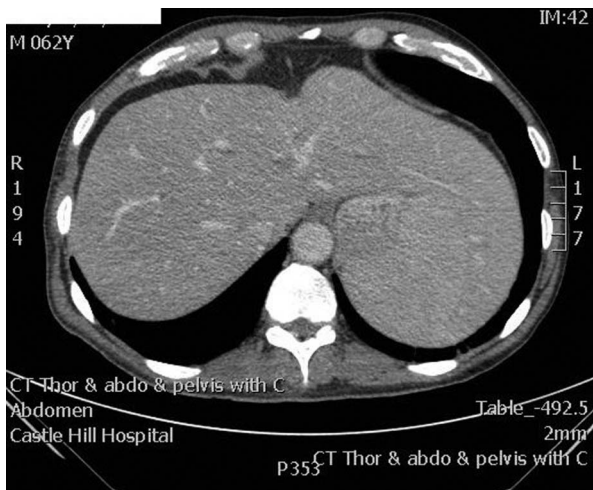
Hepatosplenomegaly on CT scan.
